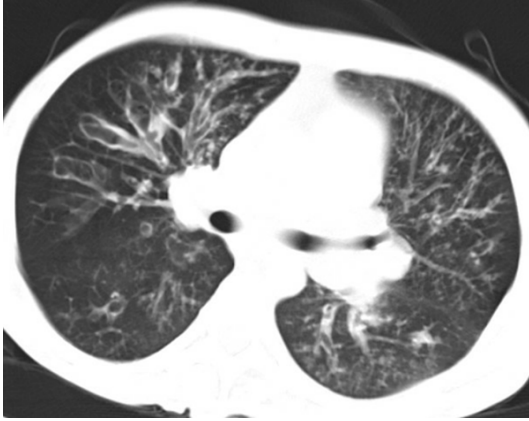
Chest computed tomography (CT) scan showed the severe bronchiectasis and peribronchovascular infiltration in both lung fields.
